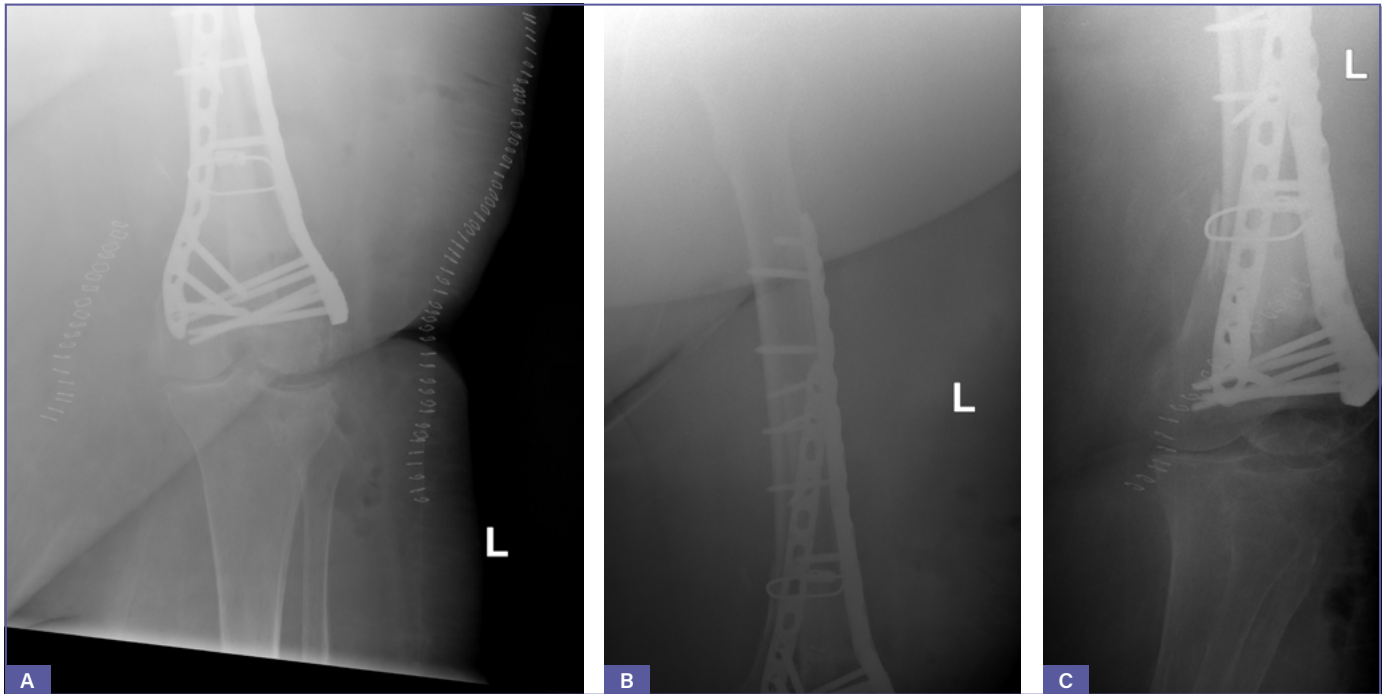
Post-operative X-rays.
